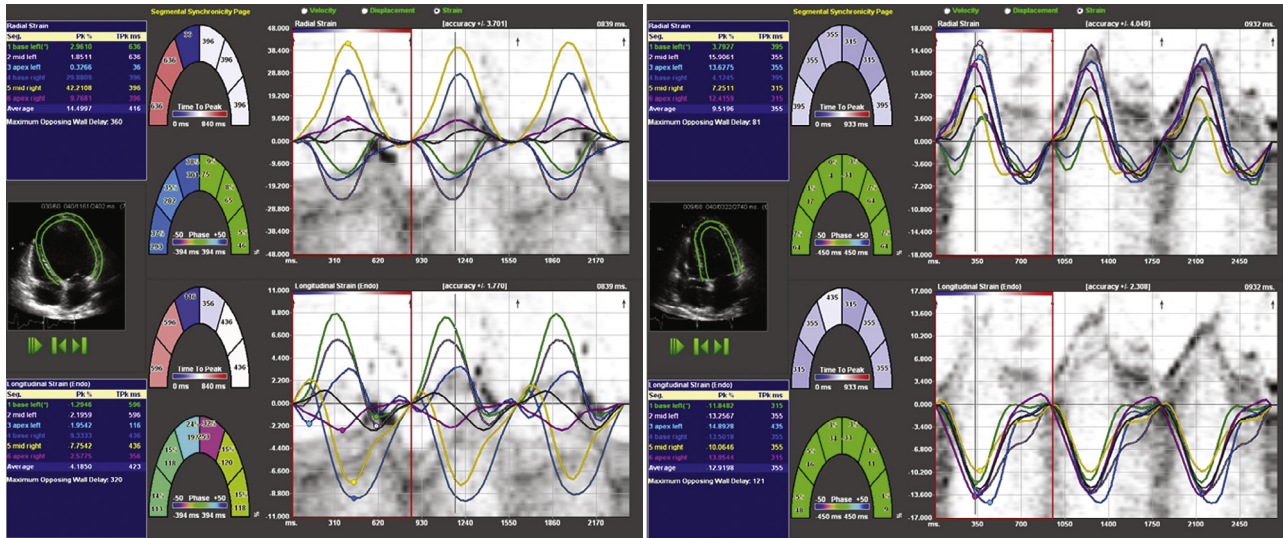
Dysynchrony versus synchrony, as assessed by myocardial strain before and after CRT. Average radial and longitudinal strain is calculated from six different regions in the ventricle on apical four-chamber views. The waveforms depicted demonstrate both timing and magnitude of peak strain in these regions. Left panel shows a patient with cardiomyopathy before therapy with a cardiac resynchronization device. Right panel shows same patient after 12 months of CRT with dramatic improvement in ventricular synchrony.
